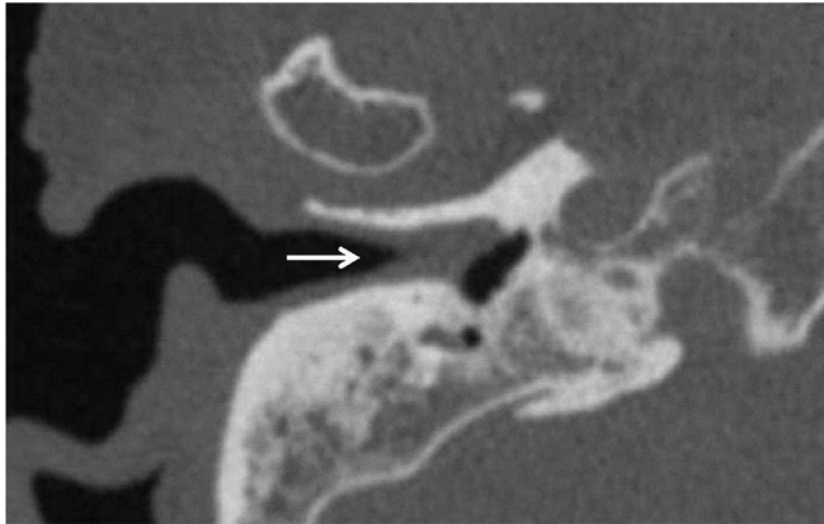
CT image (horizontal plane, right ear). A soft-tissue density area (arrow) in the medial aspect of the external auditory canal.
